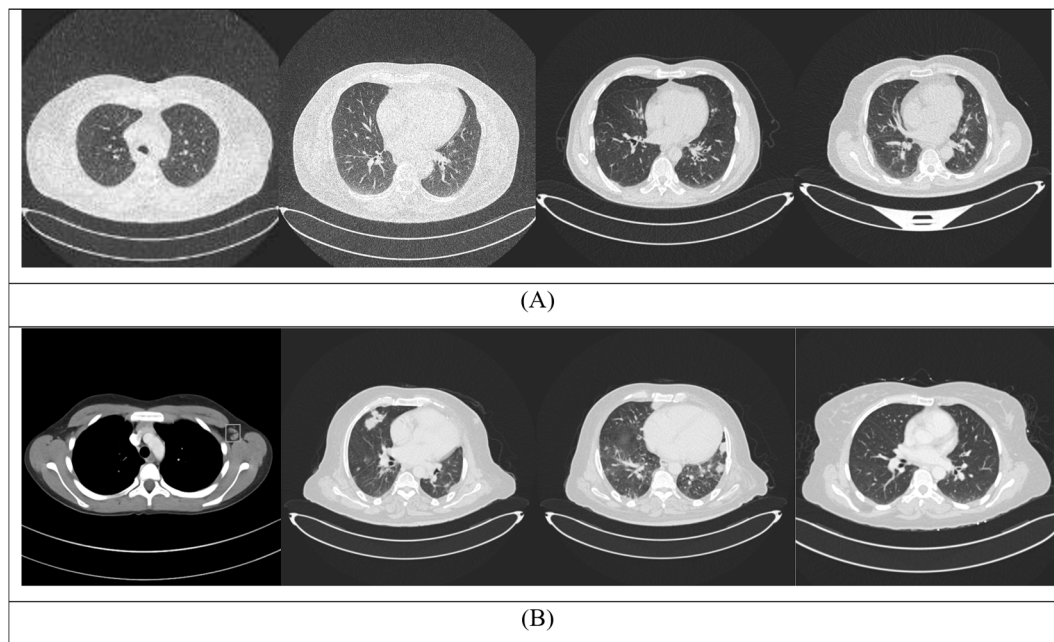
Some lung CT scans of malignant and benign cases from the IQ-OH/NCCD dataset.
